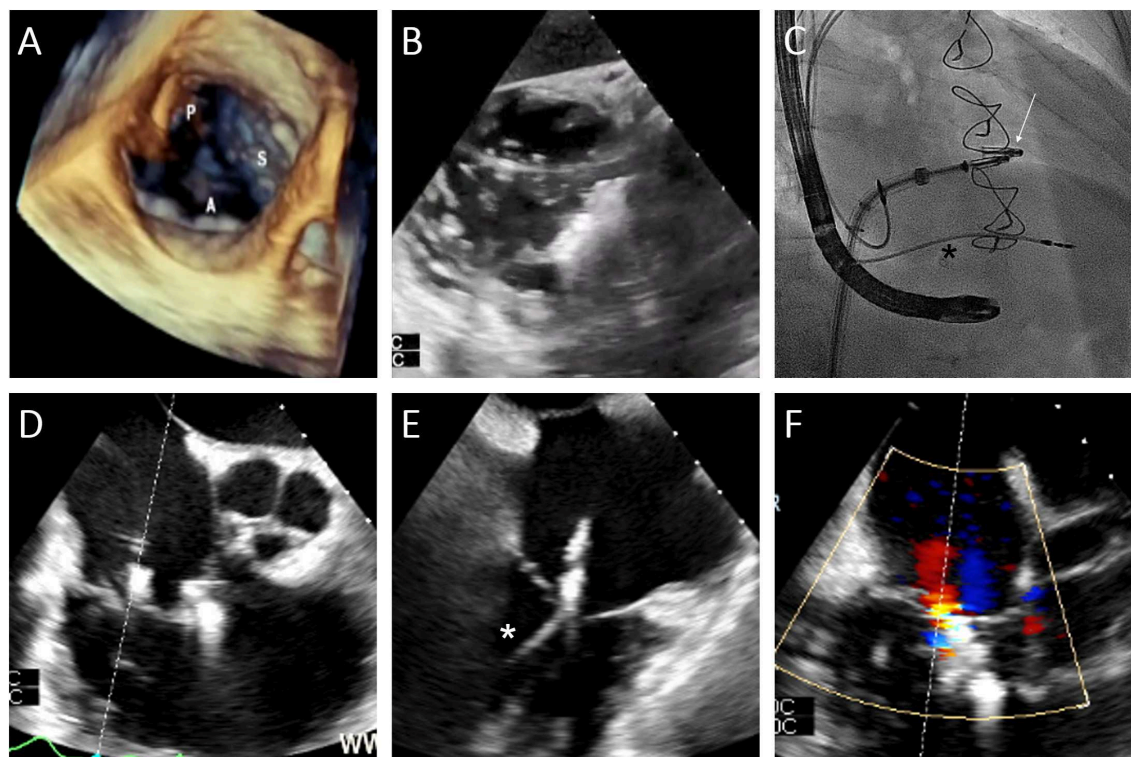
Edge-to-edge repair case. (A) Assessment of the baseline valve anatomy using transesophageal 3D echocardiography (A=anterior leaflet; S=septal; p=posterior). (B) Orientation of the clip perpendicular to the antero-septal commissure using the transgastric view. (C) Insertion of the delivery system into the right atrium under fluoroscopic guidance (projection: RAO 20) after implantation of a MitraClip in the mitral valve (arrow). (D,E) Positioning of the clip in the postero-septal commissure using x-plane mid-esophageal view (closer to the aorta is a first clip in the antero-septal commissure, *pacemaker lead). (F) Final result after implantation of 2 clips.
